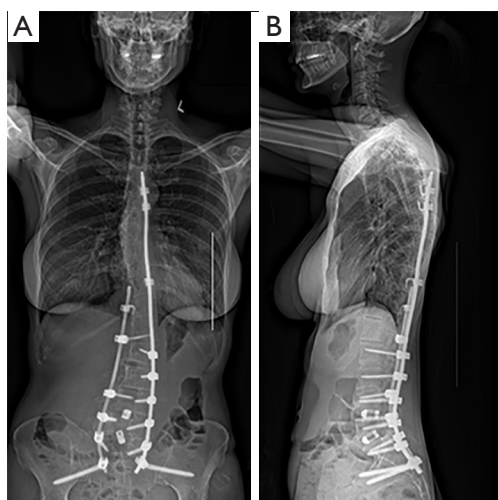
Three-foot spine x-rays obtained seven months postoperatively. (A) Posterior-anterior and (B) lateral standing three-foot spine x-rays performed in follow-up seven months postoperatively, demonstrating stable vertebral alignment and hardware positioning. Mild mid-thoracic scoliosis (convex to right) and thoracolumbar scoliosis (convex to left) are unchanged from earlier postoperative films.
